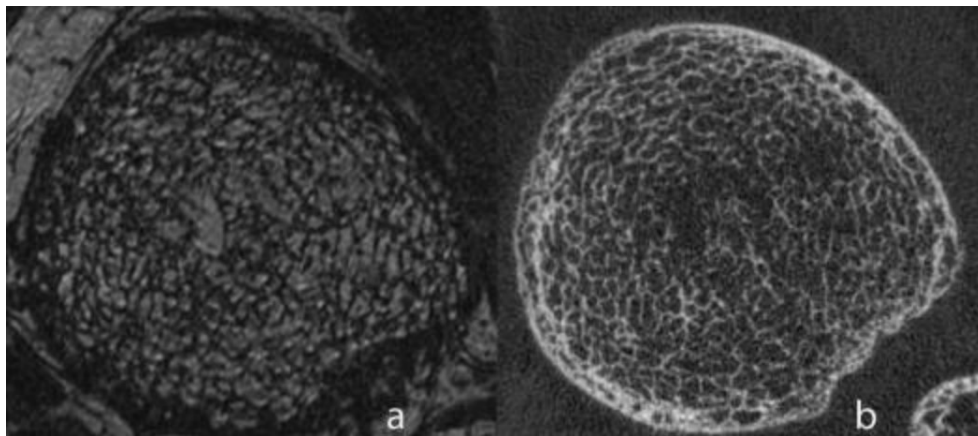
(J. Goldenstein, et al., 2010). A distal tibia acquired in (a) MRI at 3 Tesla, and (b) HR-pQCT.
